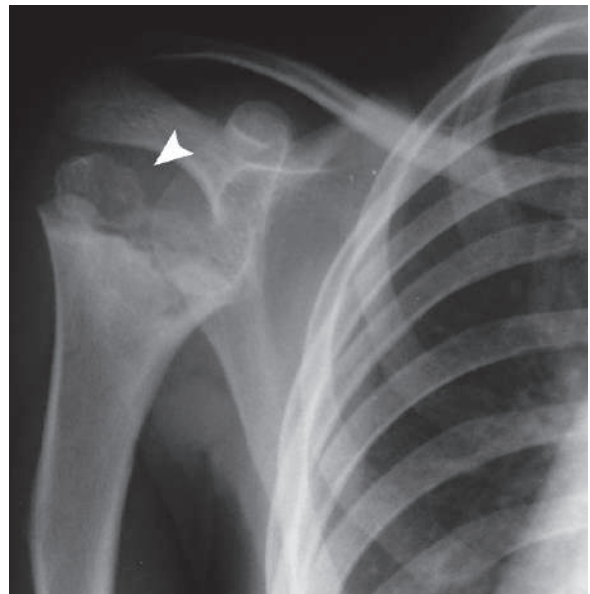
Plain right shoulder radiograph of the same patient shows severe humeral epiphysis hypoplasia and dysplasia (*arrowhead*)
